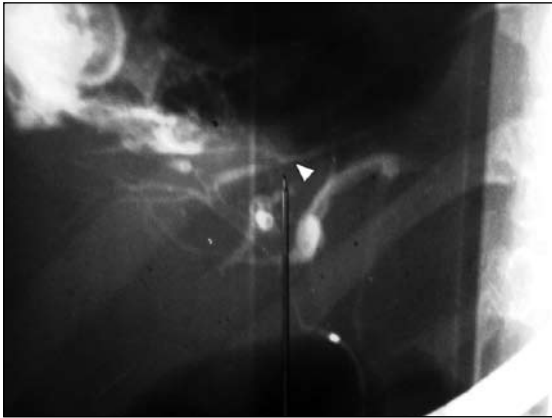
ERCP shows extravasation of the contrast agent from one of the branches of the right hepatic ducts (arrowhead). The extravasated contrast is seen to outline the cyst in the upper left corner of the radiograph.
